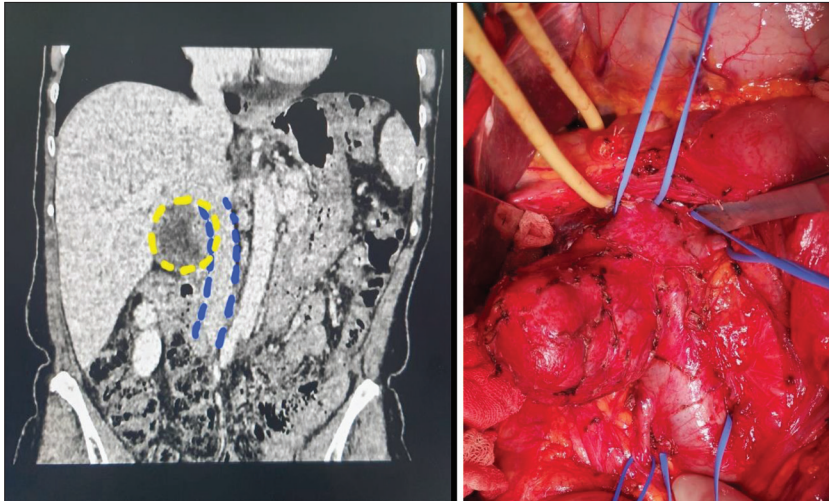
Multidetector computed tomography of the abdomen, coronal section; the yellow dashed lines mark the tumor; the blue dashed lines mark the border of the inferior vena cava (left); intraoperative finding (right); yellow tape is on the hepatoduodenal ligament, the uppermost blue tape on the inferior vena cava, left blue tape is on the left renal veins, two lower blue tapes are on the right gonadal vein and lower portion of the inferior vena cava
